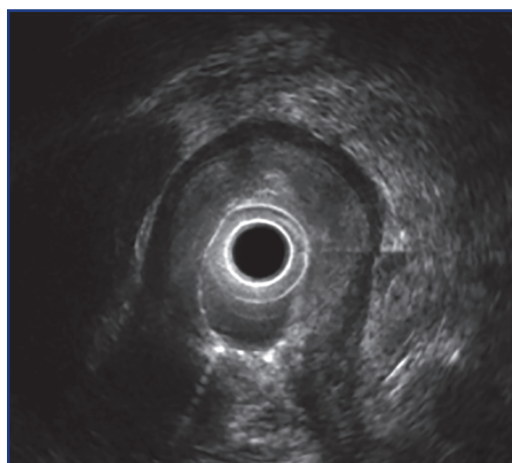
Endosonographic picture in diffuse gastric cancer [1]
